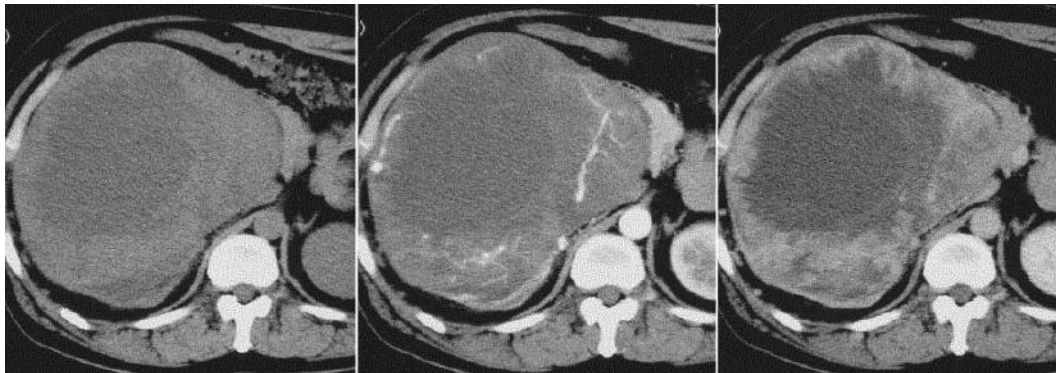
CT findings. A large right renal tumor was observed on plain CT (left). Blood vessels were enhanced in the early phase (middle), and the tumor was enhanced in the delayed phase (right).
